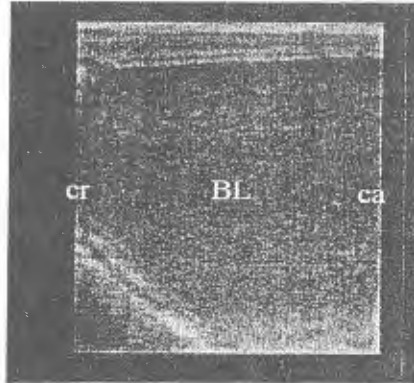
Image of bladder (BL) by trans-rectal ultrasound.
